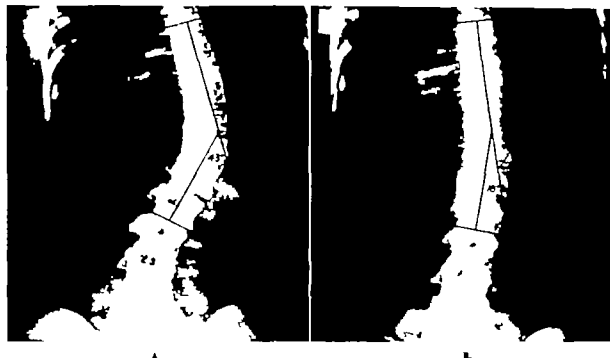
A, Roentgenogram prior to the first fusion, revealing marked list in a patient with idiopathic scoliosis. The first fusion resulted in pseudoarthrosis. B, Roentgenogram taken three years following the last fusion. (From Schmidt, A. C.: Verhandl. deutsch. orthop. Gesellsch., 41 Kongress, pp. 193-220 1954 Ferdinand Enke Verlag Stuttgart)
